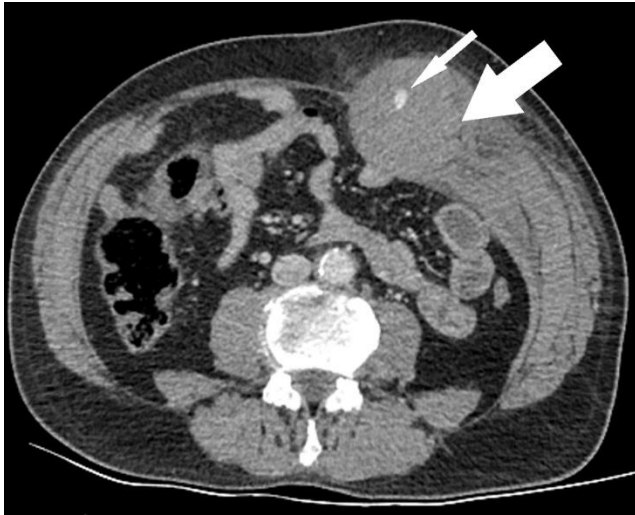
Axial contrast-enhanced abdominopelvic CT shows relatively hyper dense left sided RSH that extending to transverse and oblique abdominal muscles and fascias (thick arrow). Note the contrast extravasation (thin arrow)
